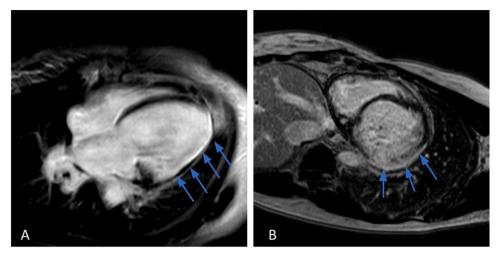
Cardiac MRI demonstrated near-transmural to transmural enhancement of the anterolateral, inferolateral, and inferior walls (blue arrows) with associated wall thinning and severe hypokinesis, in a pattern consistent with the diagnosis of cardiac sarcoidosis. MRI, magnetic resonance imaging.
